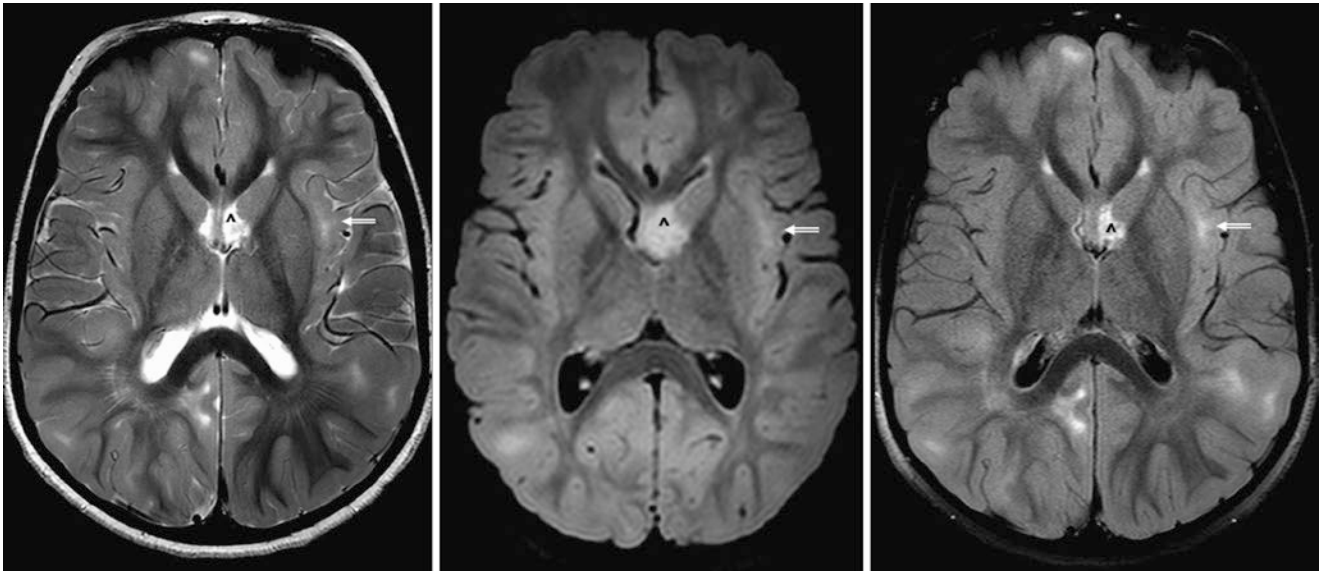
Comparison case of tuberous sclerosis (TS). A 7-year-old had a 3T MRI that showed bright foci related to tubers/hamartomas throughout the SCWM on T2WI (*left*), 3D FLAIR (*middle*), and 2D FLAIR (*right*), from TS. One focus is denoted within the SIWM
